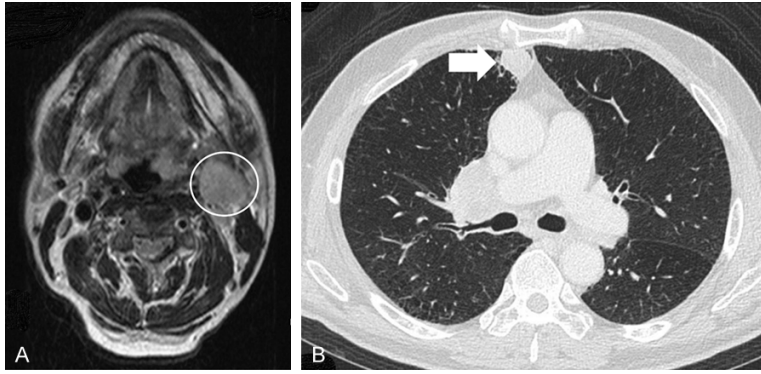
A. Magnetic resonance imaging revealed a mass in the left tonsil. B. Computed tomography revealed a single mass in the right upper lobe.
